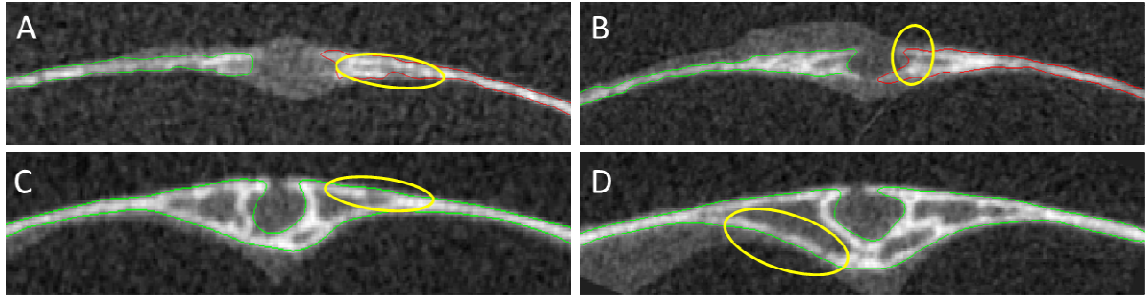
Representative  $\mu$ CT images with segmentation boundary. The algorithm was able to accurately segment the bones with low mineralization of the 6 (a) and 12 (b) day old sutures. The same algorithm parameters were able to also segment the images from the 20 (c) and 25 (d) day old sutures. The algorithm was also able to bridge discontinuous regions in images from all ages examined (yellow ovals).
